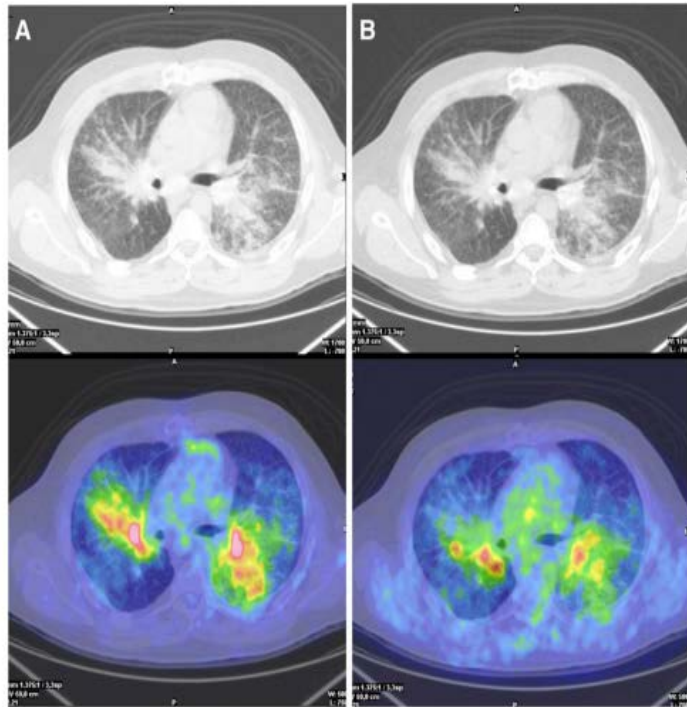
(A) On admission, chest computed tomography scan revealed bilateral ground-glass opacities. Positron emission tomography/computed tomography scan showed marked tracer uptake in the lungs bilaterally: standardized uptake value was 9.3 in the right lung and 8.5 in the left lung. (B) After 6 months of anakinra treatment, repeated positron emission tomography/computed tomography documented a marked decrease in the tracer uptake in both lungs. Standardized uptake value was 8.0 in the right lung and 5.9 in the left lung, with a standardized uptake value variation of -13% in the right lung and -31% in the left lung compared with baseline.
